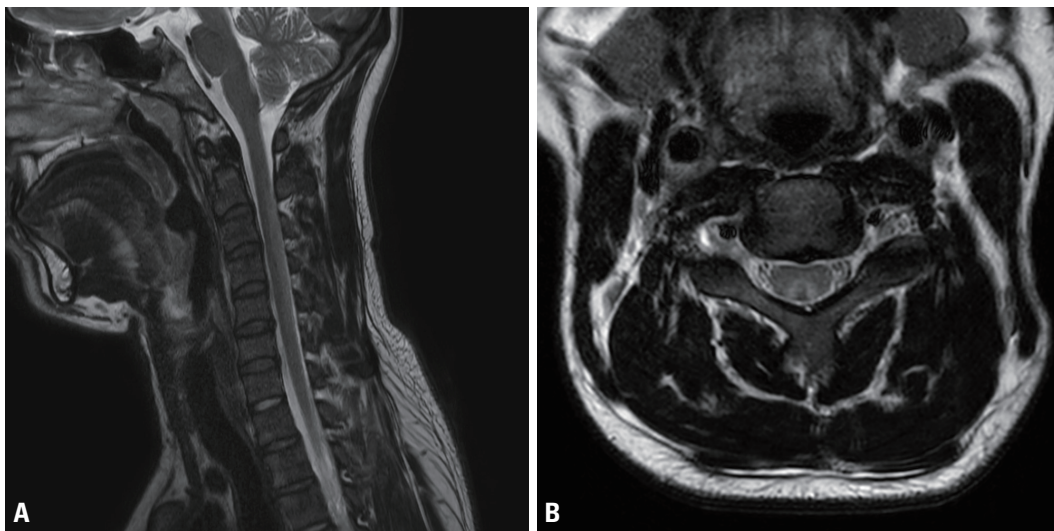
T2-weighted cervical spinal magnetic resonance imaging (patient no. 1). (A) In the sagittal series, abnormal hyperintensities were observed in the dorsal cervical spinal cord (C2-C5) without enhancement. (B) In the axial series, high signal intensity (inverted-V sign) and cord swelling were observed.
